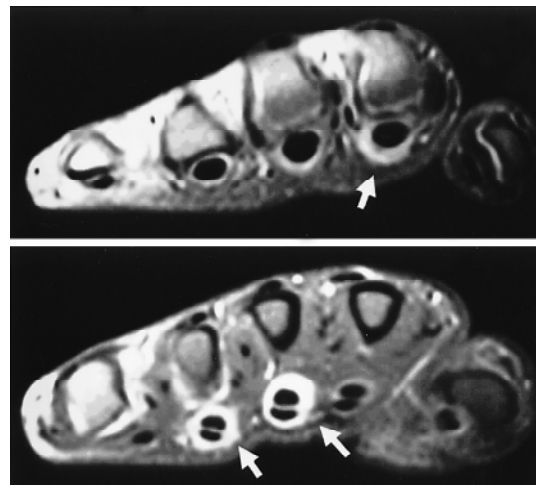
MRI images of the left hand showing gadolinium-enhanced lesions around the flexor digitorum tendons. Note that the strongly enhanced tendons are different in the two scan levels
